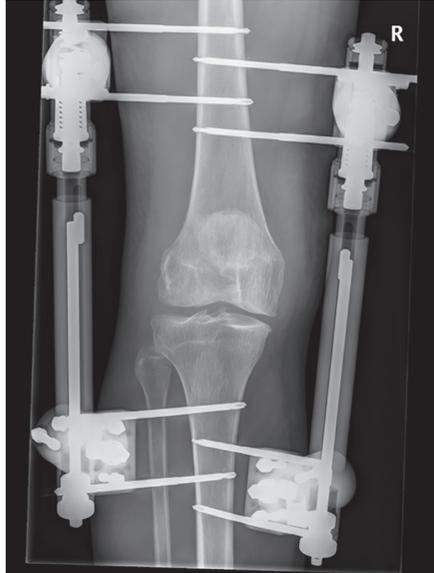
Representative radiograph of the external distraction frame in use.
